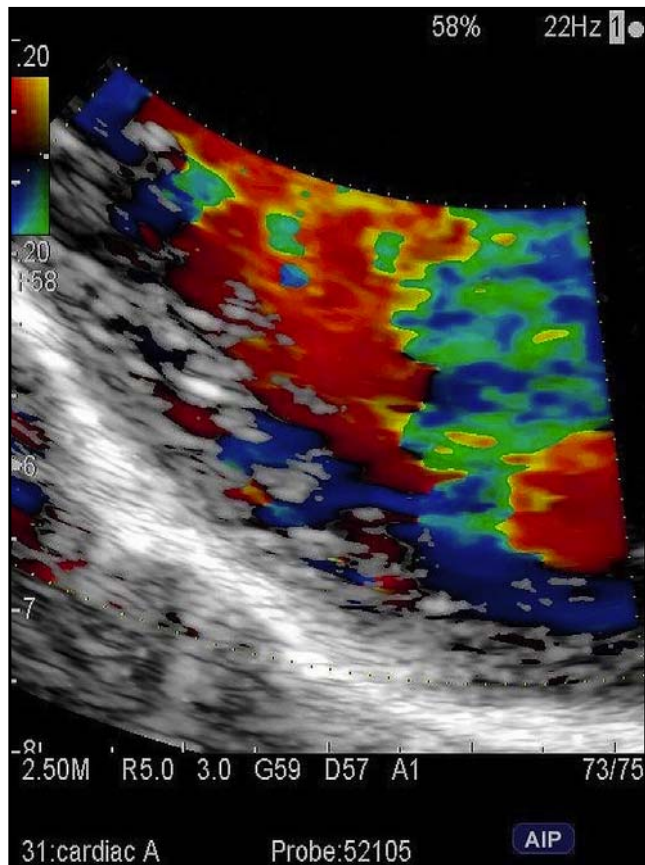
Perfusion of intertrabecular recesses in the left ventricular cavity visualised using colour Doppler echocardiography.
